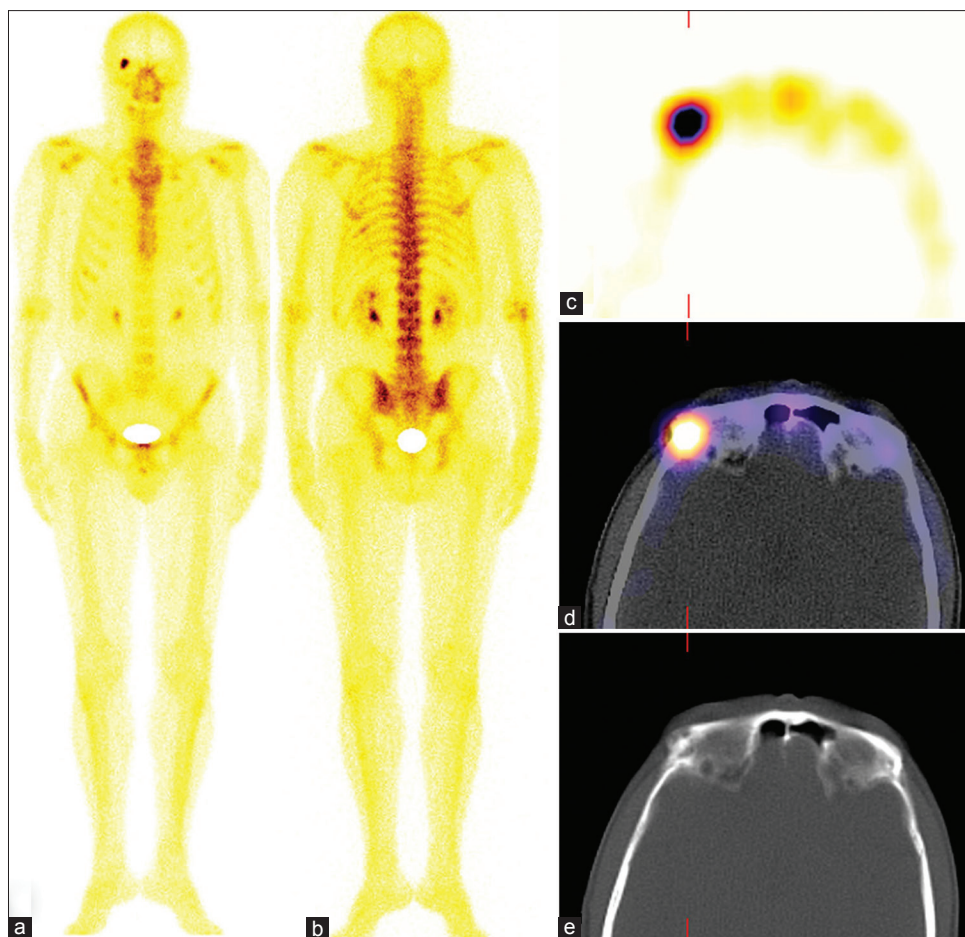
Solitary metastasis from newly diagnosed prostate cancer in a 52-year-old patient (a and b) Anterior and posterior view, respectively, of planar scintigraphy, (c-e) single-photon emission computed tomography/computed tomography and fusion SPECT/CT slice, respectively, through the lesion
